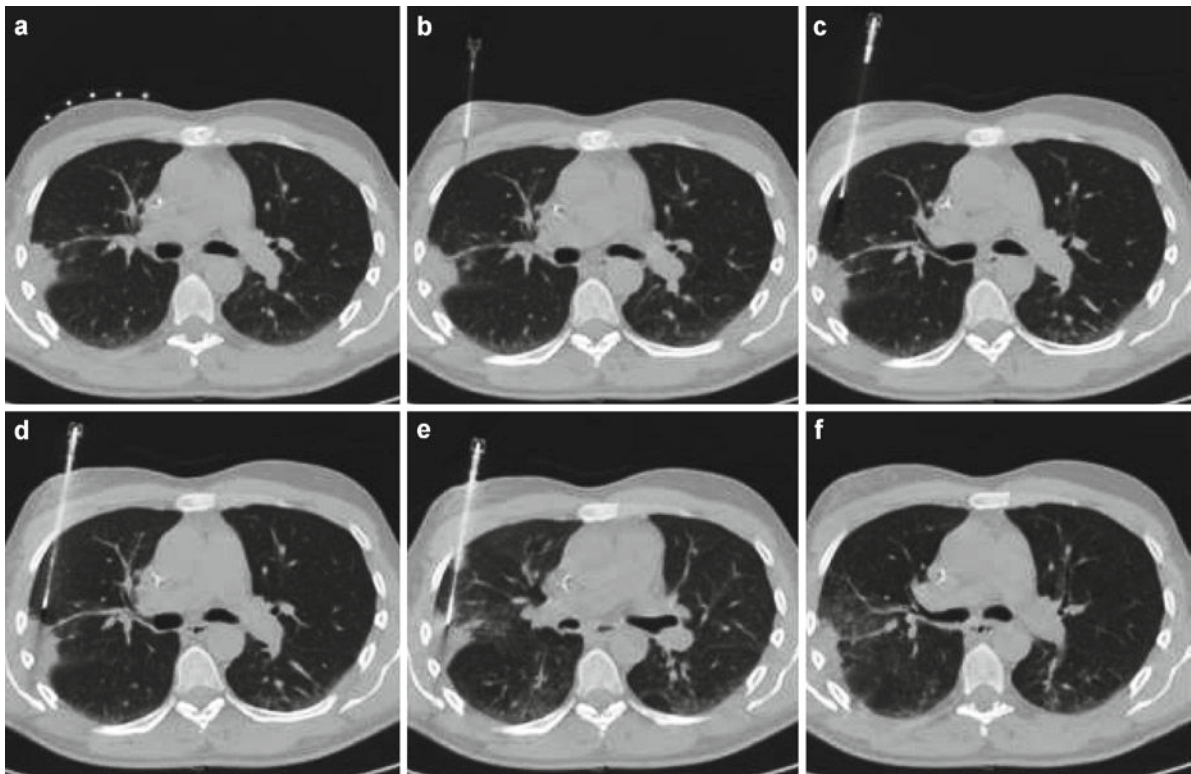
CT-guided lung biopsy in a 65-year-old patient with organizing pneumonia. The patient experienced severe pain at the end of the procedure with a vasovagal syncope. The control
